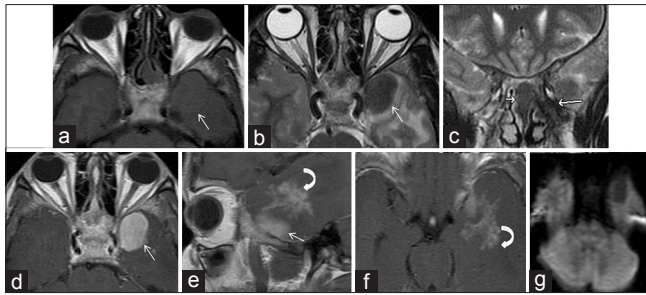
(a and b) Magnetic resonance imaging axial T1, T2-weighted images showing dural-based lesion in the left temporal region which is isointense on T1 and hypointense on T2 images. (c) Magnetic resonance imaging coronal T2-weighted image showing involvement of posterior nasal septum (small arrow) with intracranial extension (big arrow). (d-f) Magnetic resonance imaging coronal, sagittal, axial postcontrast images showing homogenous enhancement of the dural lesion (arrow) and tree-in-bud type of parenchymal enhancement (curved arrows) adjacent to the lesion (g) No restricted diffusion noted within the lesion
